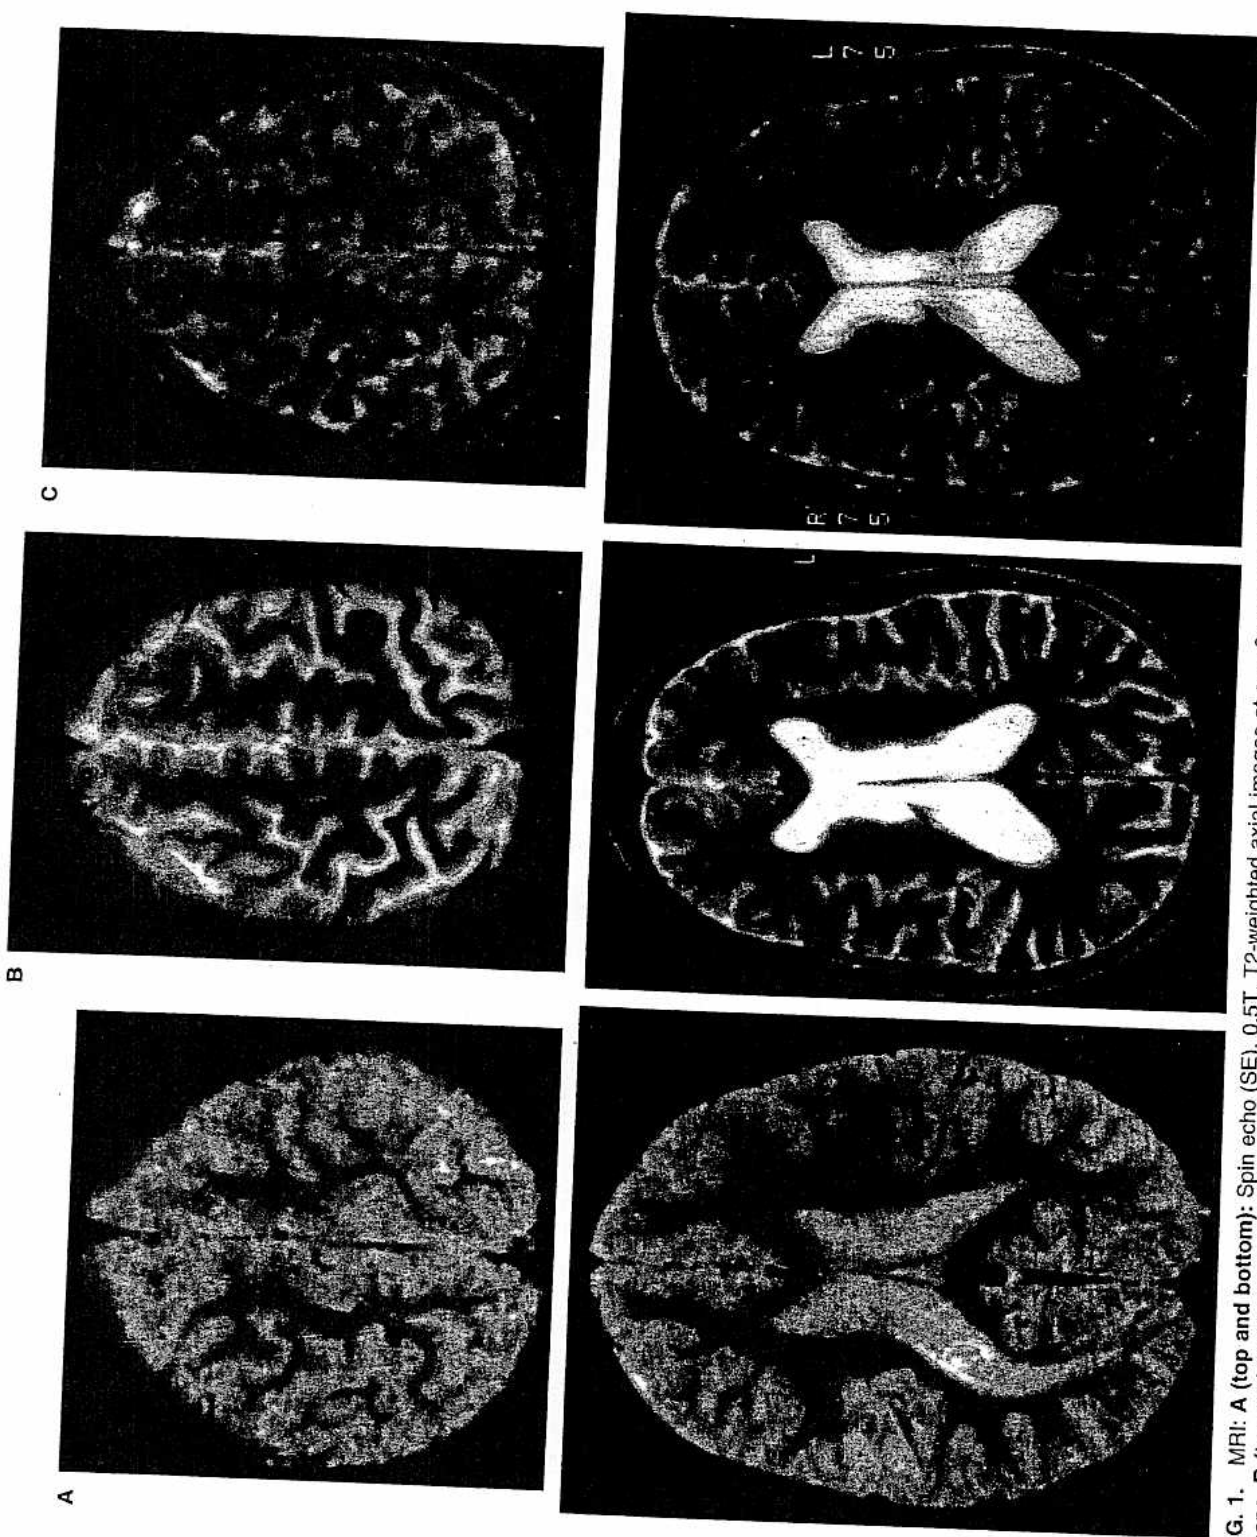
MRI: A (top and bottom): Spin echo (SE), 0.5T, T2-weighted axial images at age 6 years. Lateral ventricles are mildly enlarged, with a normal shape. B (top and bottom): Fast SE 1.5 T, T2-weighted axial images obtained at age 10 years 8 months. Marked enlargement of lateral ventricles with rounding of the ventricular cavities. Pericerebral subarachnoid spaces are also enlarged. C (top and bottom): Fast SE 1.5T, T2-weighted axial images obtained at age 11 years 3 months. The size of ventricles and subarachnoid spaces is greatly reduced in comparison to the previous MRI (B).
